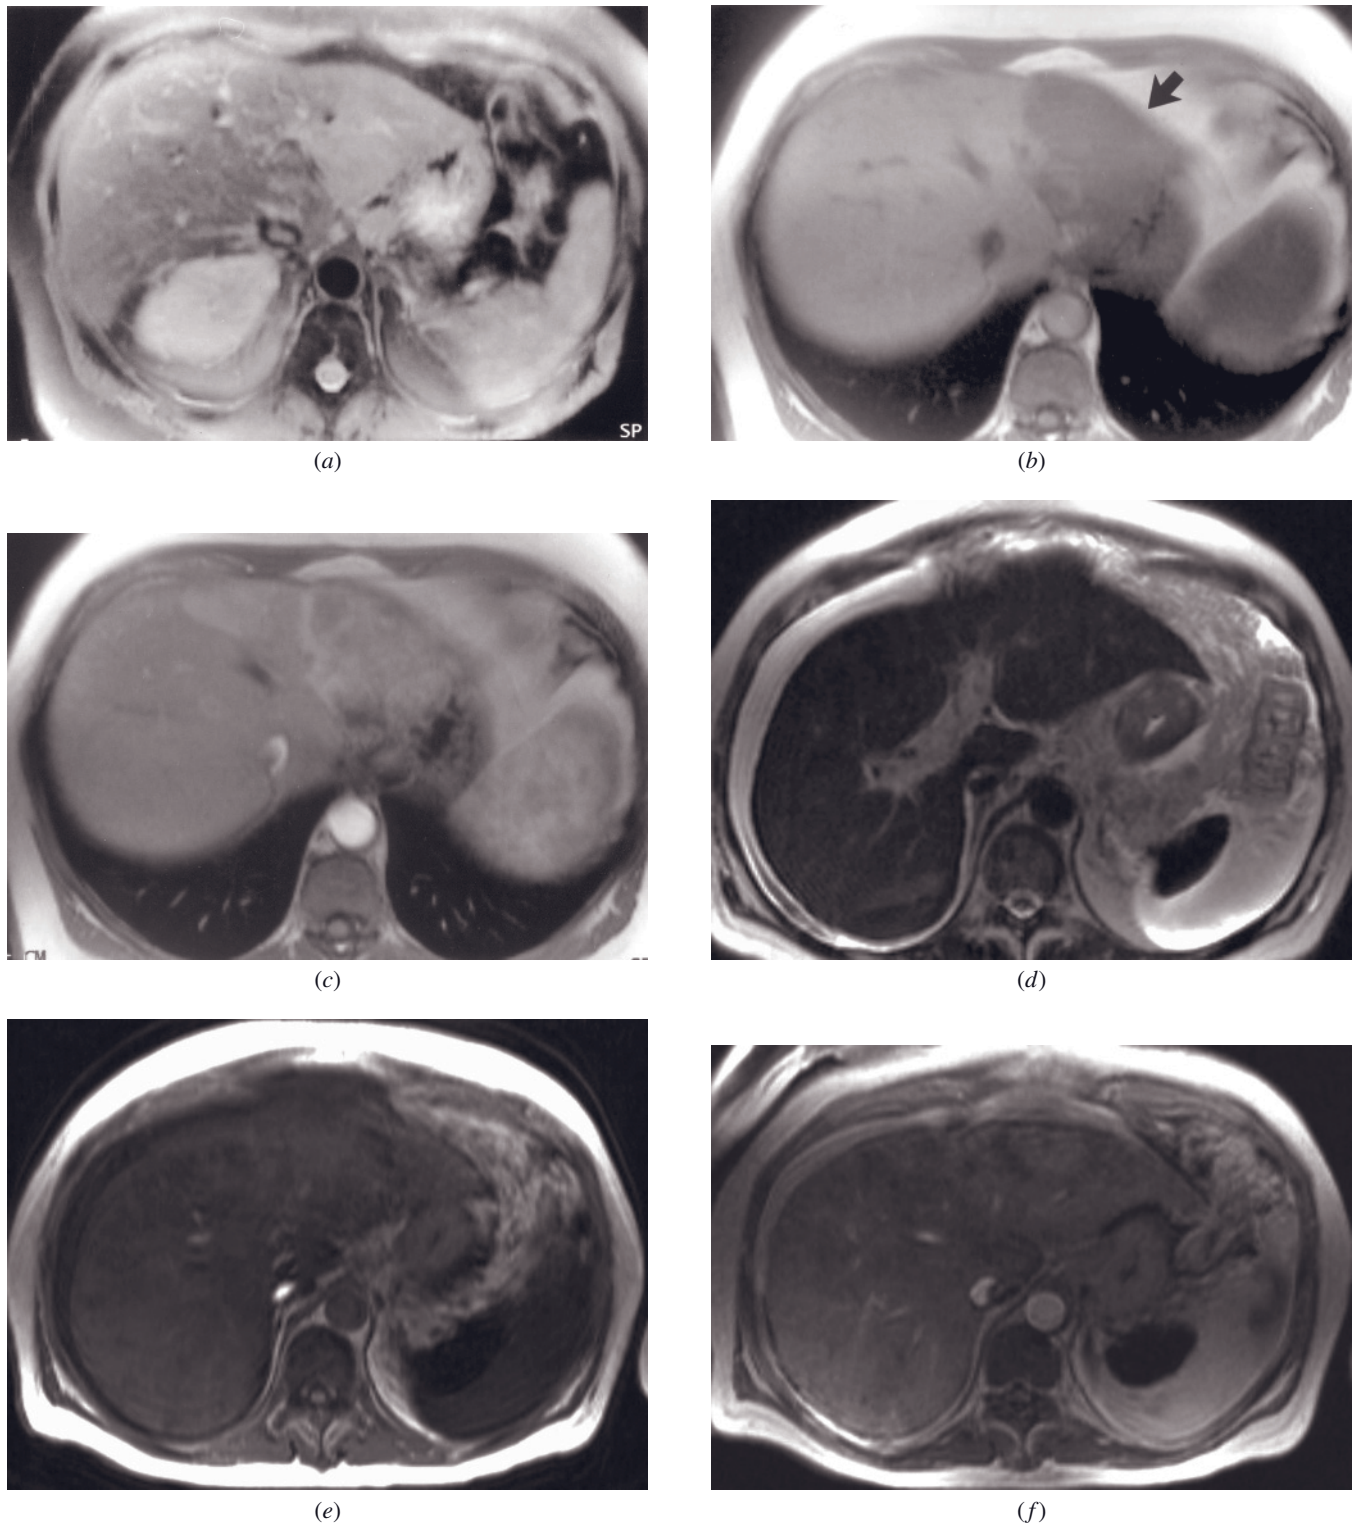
Breast cancer liver metastases—infiltrative pattern. Fat-suppressed T2-weighted SS-ETSE (*a*), SGE (*b*), and immediate postgadolinium SGE (*c*) images. There is a mass (arrow, *b*) in the left hepatic lobe that demonstrates slightly increased signal on T2-weighted (*a*), decreased signal on T1-weighted (*b*), and heterogeneous enhancement on immediate postgadolinium SGE (*c*) images, consistent with metastatic disease. The confluent involvement of a segment, as in this case, is characteristic of breast cancer but represents an uncommon pattern.
